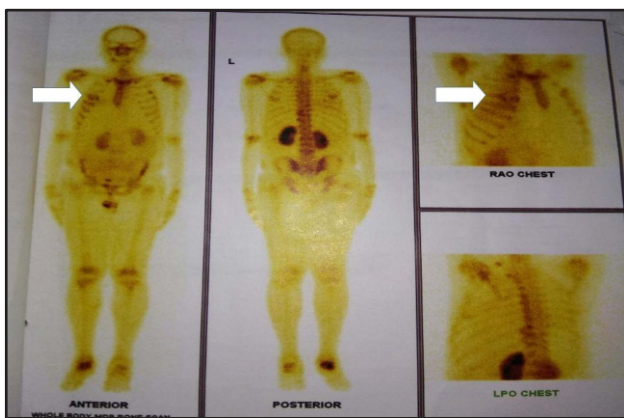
Whole body Tc99m MDP scintigraphy showed increased radiotracer concentration in right 4th rib anteriorly (White arrow over 4th rib)
